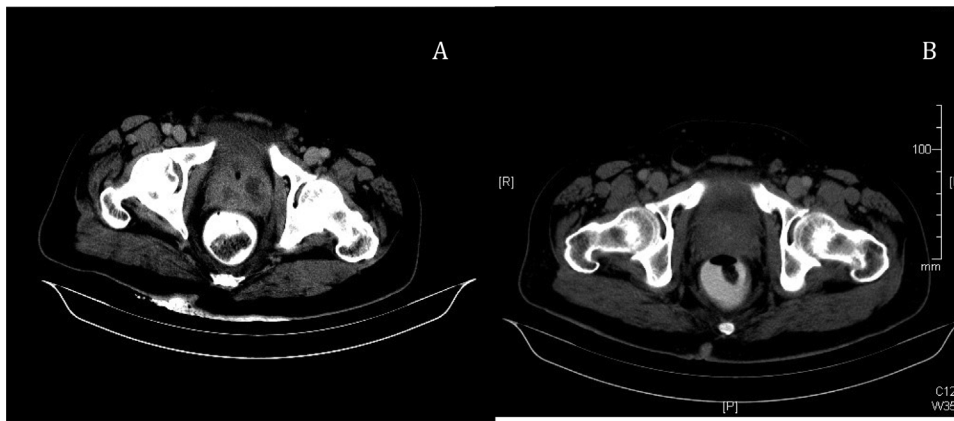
A: Computed tomography examination showing multiple hypodensities representing abscesses. B: Computed tomography examination after 4 weeks of treatment showing resolution of hypodensities within the prostate.
